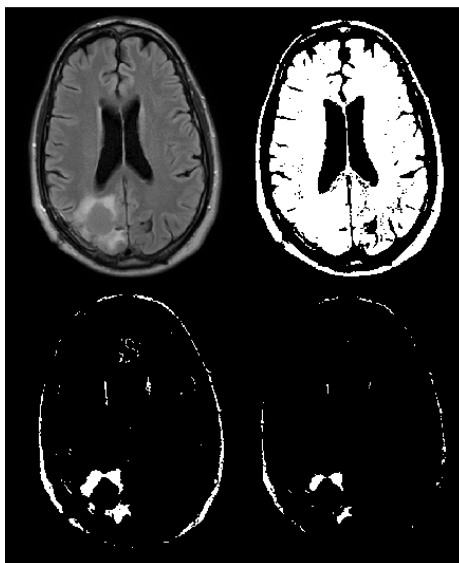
Thresholding results on one slice from FLAIR. The top left is the slice in FLAIR and top right is the result of thresholding with th_1 . The bottom images are the results obtained by thresholding with th_2 on Flair.
